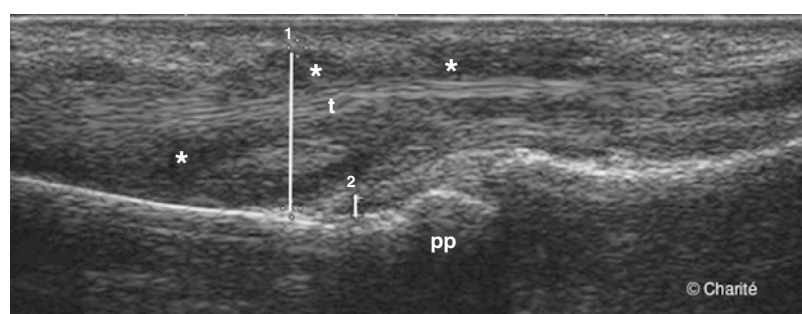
Ultrasound identifies tenosynovitis (*stars*) of the flexor digitorum tendon (t). pp, proximal phalanx.
